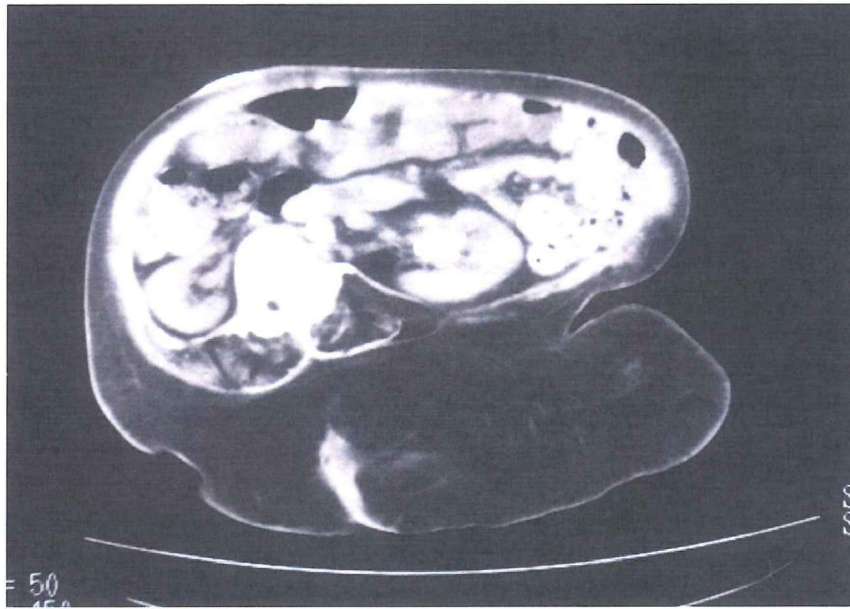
CT image of patient with back abnormality precluding treatment of her renal stone with either ESWL or PCNL.
